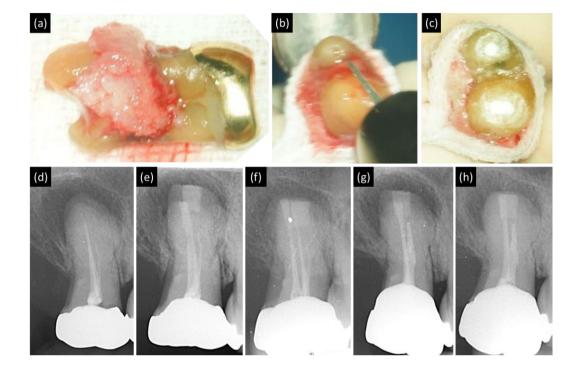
Intentional replantation on #17; (a) Pre-treatment state (Granulation tissue was observed in the furcation and mid 1/3 area), (b) Root end resection, and (c) Just before repositioning (Only the granulation in the furcation area was removed and the remaining granulation in the mid 1/3 area was left intact. (d)~(h) Periapical view on #17; (d) Preoperative, (e) Immediate postoperative, (f) 9-month follow-up, (g) 1-year follow-up (Increased PAR), and re-RCT (h) 9-month follow up (incomplete healing)
